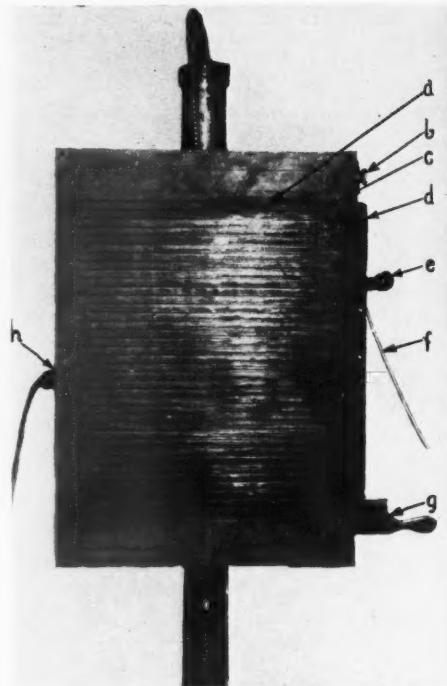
Front view of kymograph, showing detail of interchangeable lead grid. (a) Slit 0.4 mm. wide; (b) adjustable timer control for Potter-Bucky pump; (c) 12 mm. space between slits; (d) cassette; (e) cocking lever of Potter-Bucky pump; (f) release cord for Potter-Bucky pump; (g) cassette holder; (h) x-ray contact plug.
